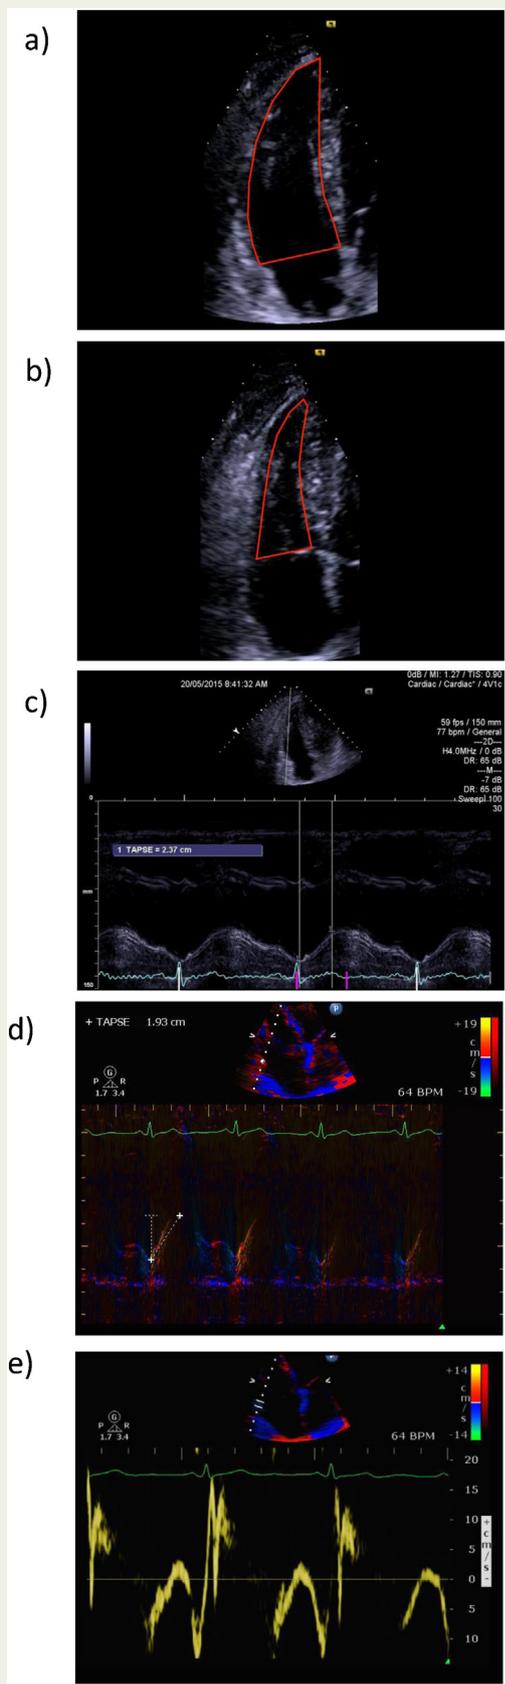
Measurement of right ventricular (RV) function from an RV-focussed apical 4-chamber view.
